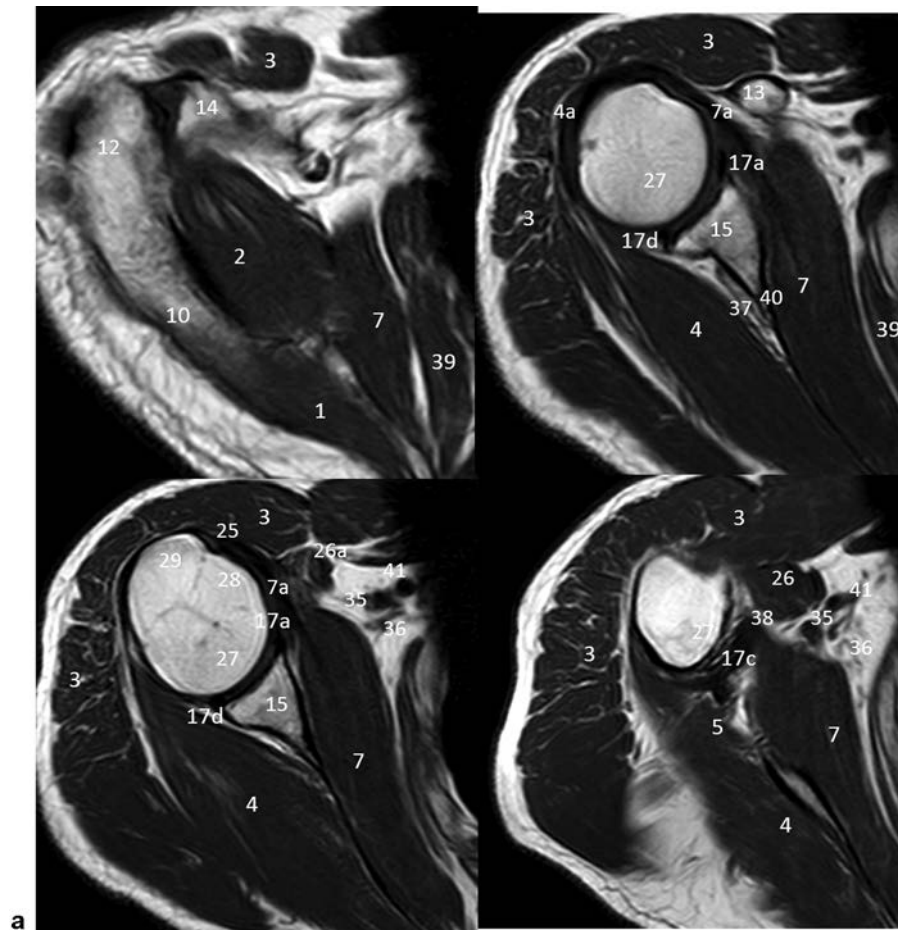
MRI anatomy. (a) Axial. (b) Coronal. (c) Sagittal. 1. Trapezius muscle. 2. Supraspinatus muscle; 2a. supraspinatus tendon. 3. Deltoid muscle. 4. Infraspinatus muscle; 4a. infraspinatus tendon. 5. Teres minor muscle; 5a. teres minor tendon. 6. Teres major muscle. 7. Subscapularis muscle; 7a. subscapularis tendon. 8. Suprascapular fossa. 9. Infrascapular fossa. 10. Spine of scapula. 11. Body of the scapula. 12. Acromion. 13. Coracoid process. 14. Clavicle. 15. Glenoid. 16. Glenoid tuberosity. 17a. Anterior labrum; 17b. superior labrum; 17c. inferior labrum; 17d. posterior labrum. 18. Coracohumeral ligament. 19. Coracoclavicular ligament. 20. Triceps long portion. 21. Coracobrachial. 22. Pectoralis minor tendon. 23. Pectoralis major. 24. Coracoacromial ligament. 25. Long head of biceps tendon. 26. Biceps brachii muscle; 26a. short head of the biceps tendon. 27. Humeral head. 28. Lesser tubercle. 29. Greater tubercle. 30. Surgical neck. 31. Humeral shaft. 32. Bicipital groove. 33. Posterior circumflex humeral artery and axillary nerve. 34. Circumflex scapular artery. 35. Axillary artery. 36. Brachial plexus. 37. Suprascapular artery and nerve. 38. Inferior glenohumeral ligament/capsule. 39. Serratus. 40. Scapular notch. 41. Axillary vein.
